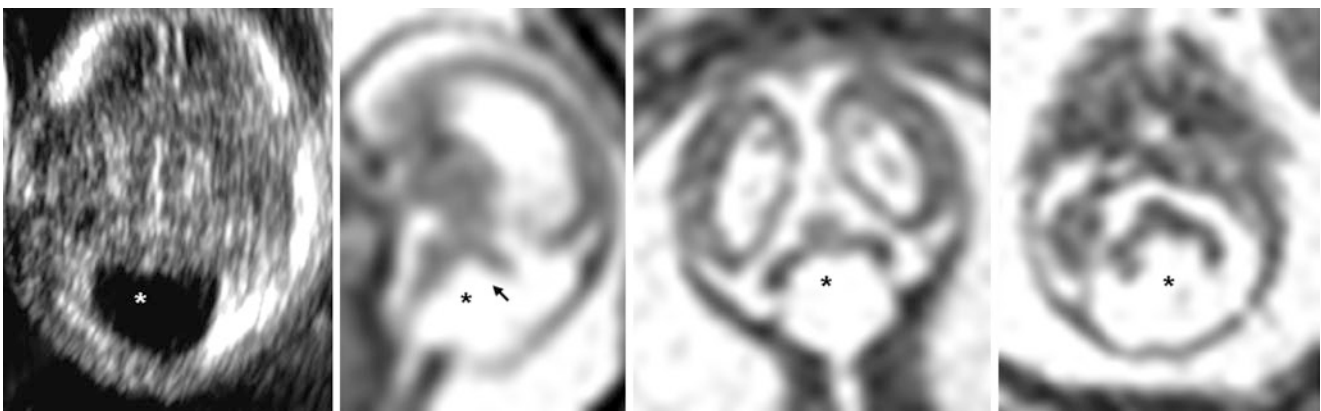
Comparison case of Dandy-Walker malformation (DWM). A 19-week-old fetus had a cystic-appearing posterior fossa (*) on US (*left*), confirmed on fetal MRI fast T2WIs in sagittal (*left middle*), coronal (*right middle*), and axial (*right*) planes. There was a mildly enlarged
